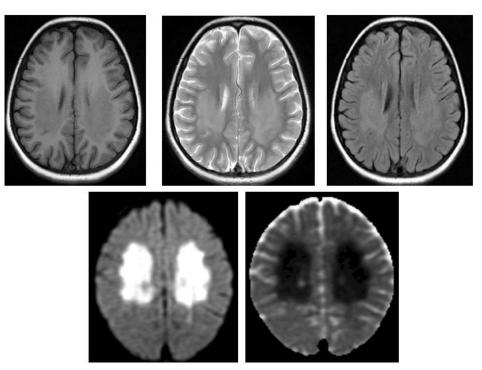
T1 hypo, T2 & FLAIR hyperintensities with DWI restrictions in bilateral parietal regions – s/o PRES with cytotoxic edema
